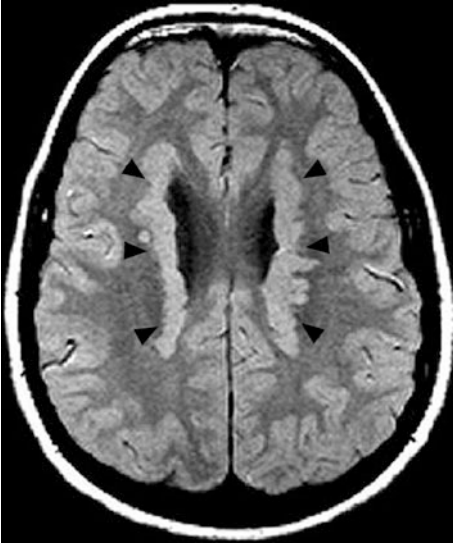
Brain MRI: Axial section. Typical, classical bilateral PNH in a woman with a missense *FLNA* mutation. Bilateral nodules of subependymal heterotopia are contiguous and rather symmetric, extensively lining the ventricular walls (black arrows)
